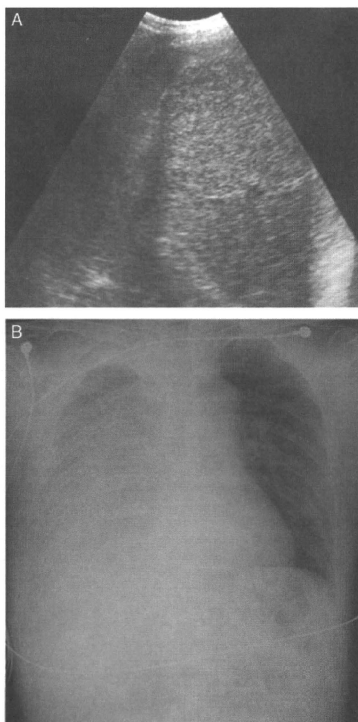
A case of hemothorax. A, A 55-year-old man with hemothorax after radiofrequency ablation, diagnosed based on an echo-free space in the right thorax on ultrasonography. B, Chest x-ray. Fluid was compressing the thorax, resulting atelectasis in the right lung.
